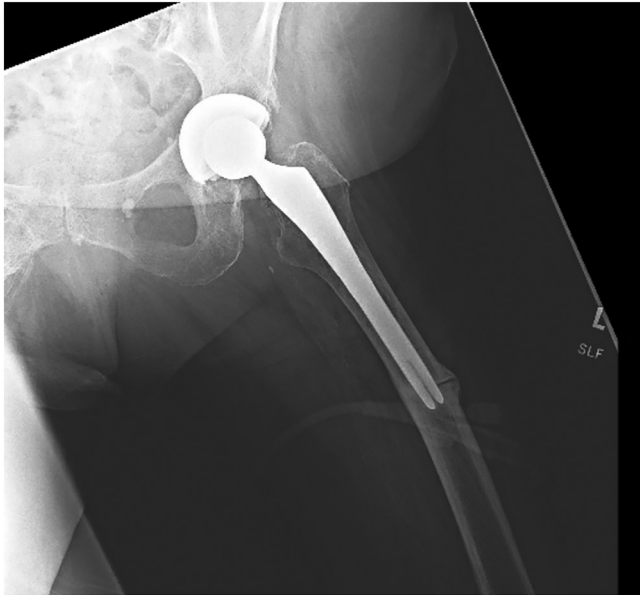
Radiograph of a patient previously treated with alendronate for osteoporosis who underwent THA, subsequently developed atraumatic thigh pain, and was found to have an atypical femur fracture. It was treated with open reduction and internal fixation.
